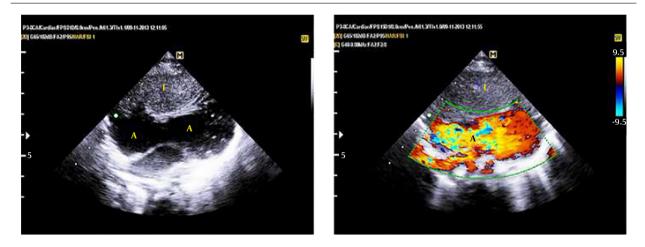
Subcostal two-dimensional echocardiogram on the left shows the huge CGRAA, with an oblique lie from right and anterior to left and posterior of the heart. The right image shows the appearance of blood flow within the aneurysm by lowering the Nyquist frequency to about 10 cycles/second.
